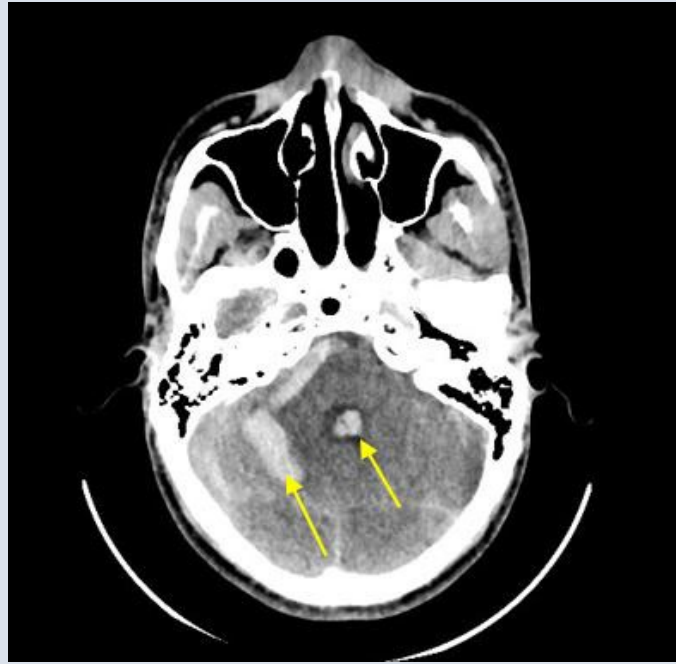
B - Noncontrast head CT shows a right-sided cerebellar subarachnoid hemorrhage, blood within all four ventricles and a right-sided parenchymal pontine hematoma.
